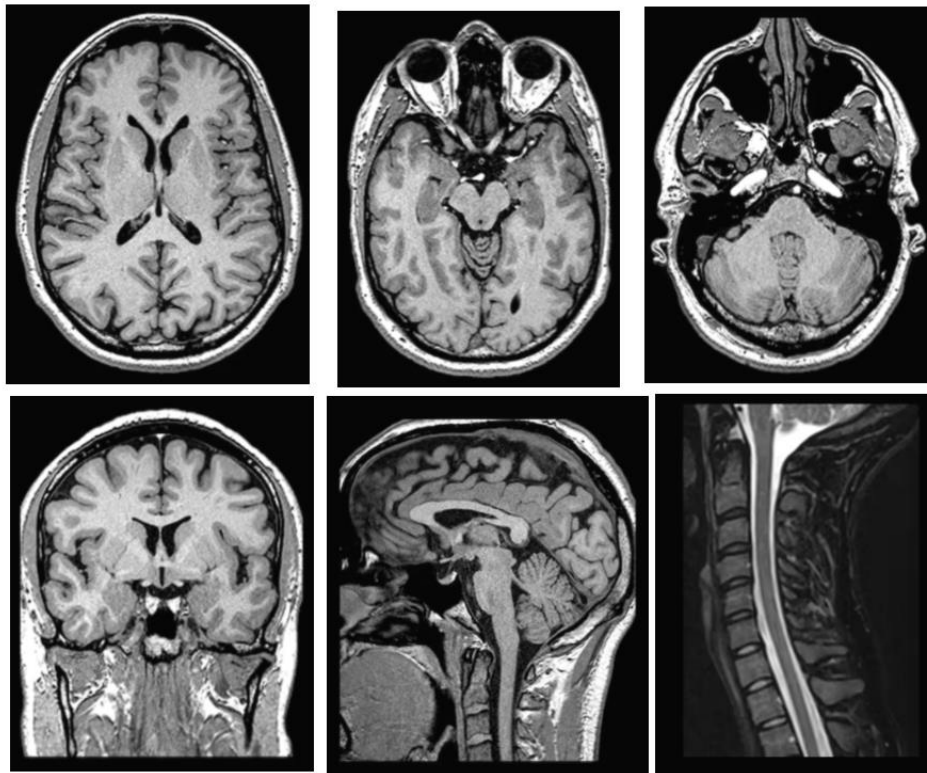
MRI brain and cervical spine showing normal findings
